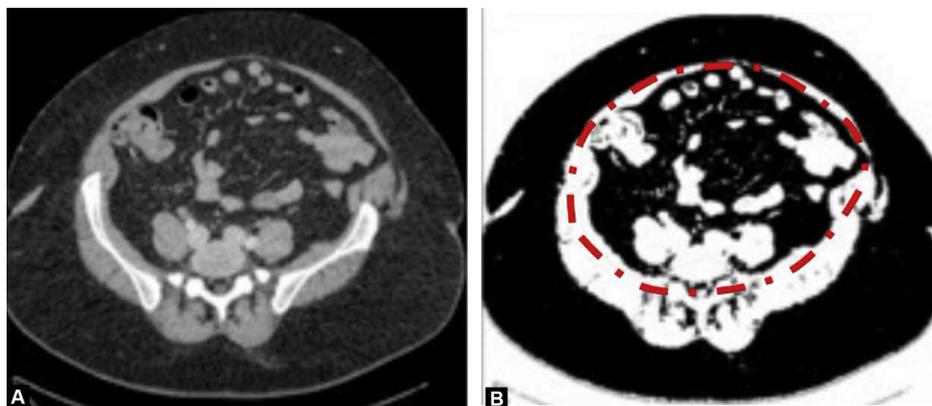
A. Figure shows CT image in the axial plane at the level of the fifth lumbar vertebra (L4) and at the level of the umbilicus. B. Figure shows automatic segmentation according to the density of the fat area.
